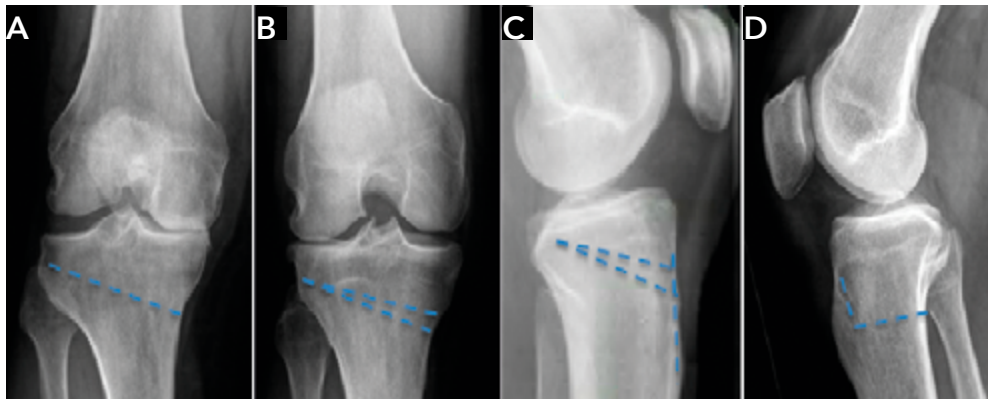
Preoperative anteroposterior/lateral radiographs of high tibial osteotomy (HTO) with projected osteotomy cuts (striped lines). A Right knee before opening wedge HTO, B right knee before medial closing wedge HTO, C left knee before anterior closing wedge HTO, and D right knee before derotation osteotomy.
